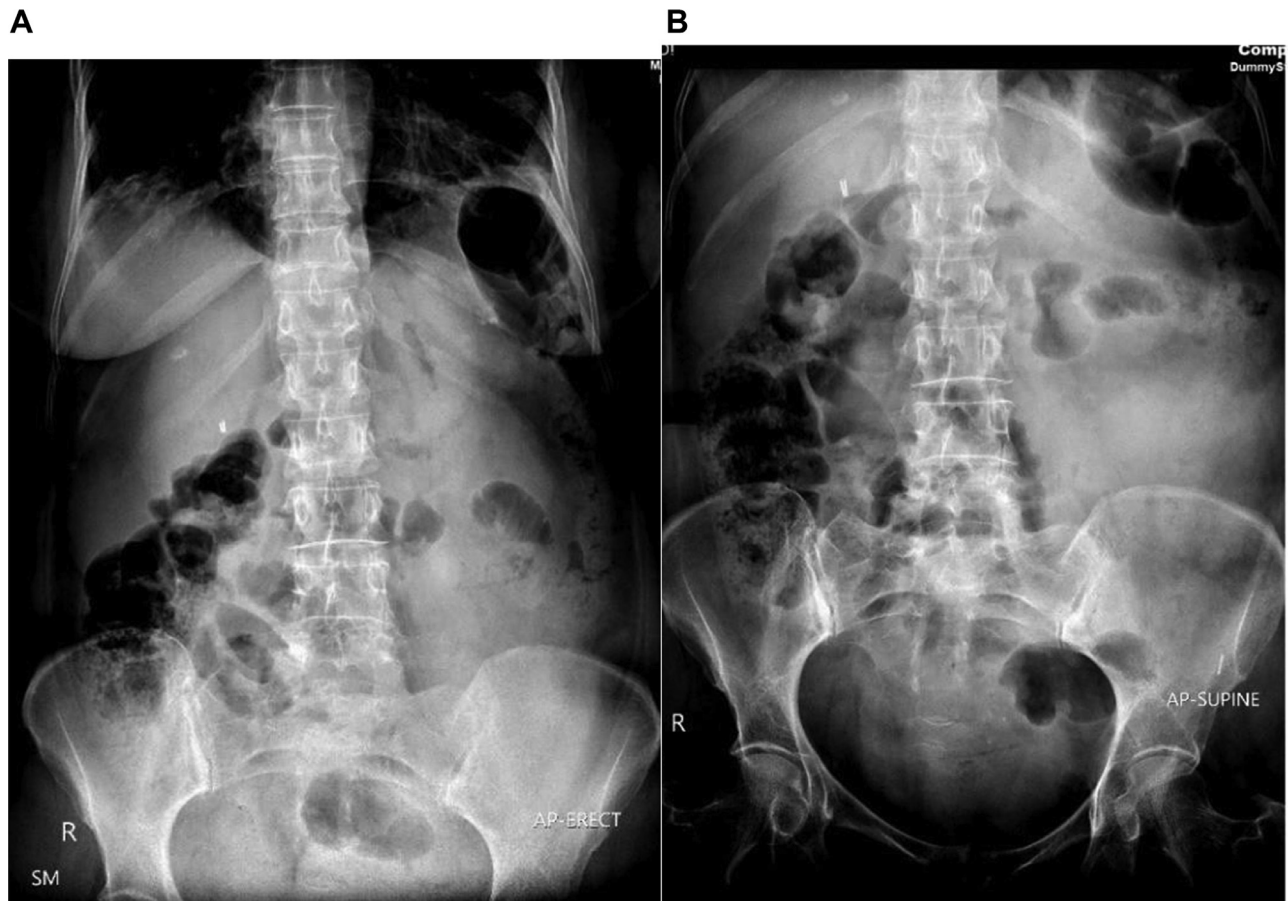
X-ray AP erect (A) and supine (B) showing an increased soft tissue density in left lumbar region, faecal loading of large bowel loops and surgical staples in right hypochondrium. No abnormal air-fluid levels seen and there is no evidence of free intraperitoneal air.
